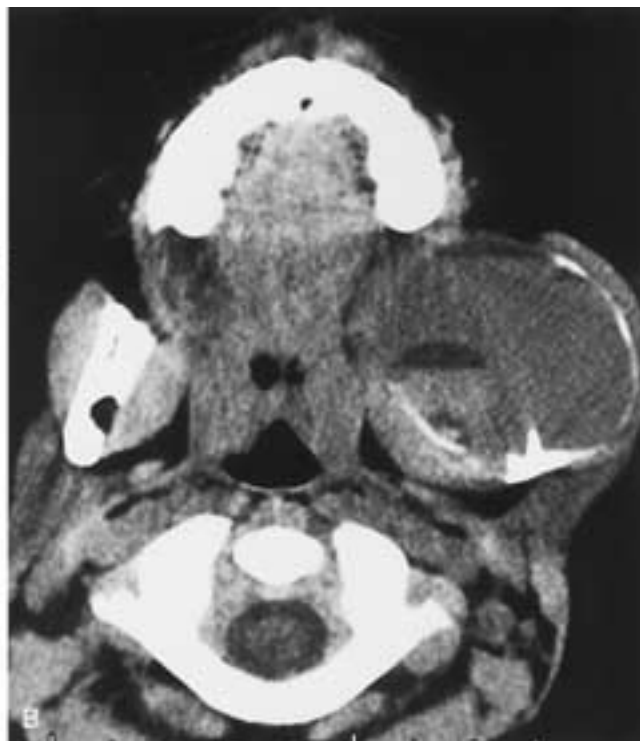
Aneurysmal bone cyst of the left mandible. A, Coronal CT through the posterior portion of the mandible shows an expansile lesion in the left mandible. Note the thin, bony rim around the cyst and misplacement of teeth in the mandible at the lower aspect of the cyst. B, Axial CT through the ascending ramus of the mandible shows a cystic, expansile lesion with several fluid-fluid levels.
